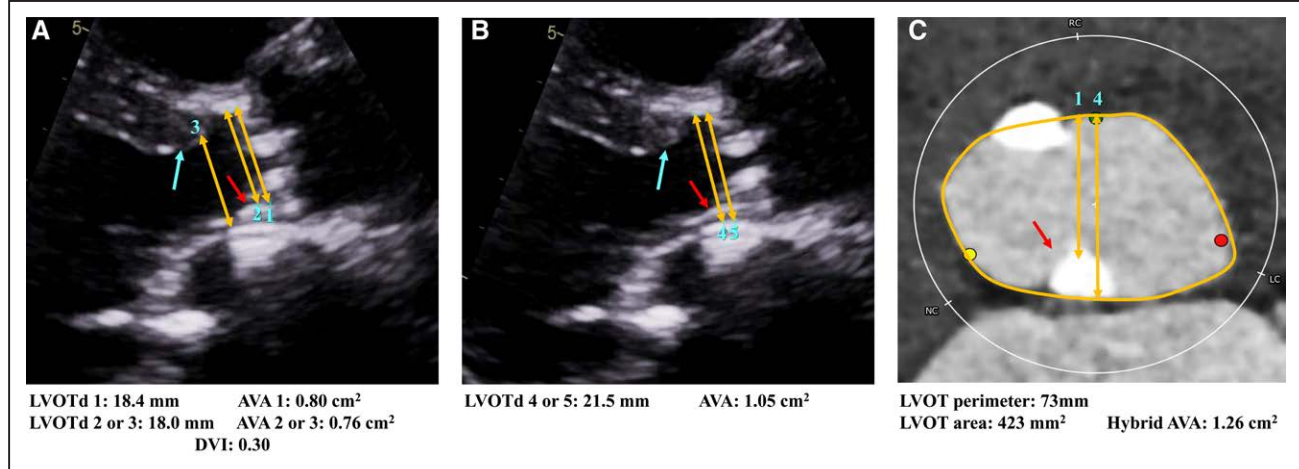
Measurement of left ventricular outflow tract (LVOT) diameter (LVOTd) in patients with aortic stenosis (AS) and chronic kidney disease (CKD). This patient has a prominent septal bulge (green arrow) and severe calcifications of the aortic valve leaflets and annulus extending posteriorly into the LVOT (red arrows). A, Measures 1 and 2 of the LVOTd are performed at (1) or close to (2) the aortic annulus, but posteriorly, the cursor is positioned at the inner border of the calcification bar (red arrow), not at the inner edge of the LVOT. Measure 3 is performed ≈ 5 to 10 mm below the annulus, and anteriorly, the cursor is located at the border of the septal bulge (green arrow). All these measures of LVOTd yield an underestimation of the LVOTd and thus of stroke volume and AVA by the continuity equation and would categorize the stenosis as severe. The Doppler velocity index (DVI) is, however, nonsevere, which raises the suspicion for underestimation of LVOTd. B, Correct measure of LVOTd performed at (5) or close to (4) the aortic annulus, therefore avoiding the region of the septal bulge (green arrow) anteriorly. In addition, posteriorly, the cursor is positioned at the inner edge of the LVOT and excludes the calcification (red arrow). C, Assessment by contrast computed tomography demonstrating the underestimation of the LVOTd by measure 1, while measure 4 is correct. Learning points: Particular attention should be paid to exclude these calcifications from the LVOT measure to avoid underestimation of LVOTd and thus of stroke volume and AVA. Hence, in patients with AS and CKD, it is preferable to measure the LVOTd at the level of aortic annulus, ie, at the base of the aortic valve cusps, or within 2 mm below the annulus.
